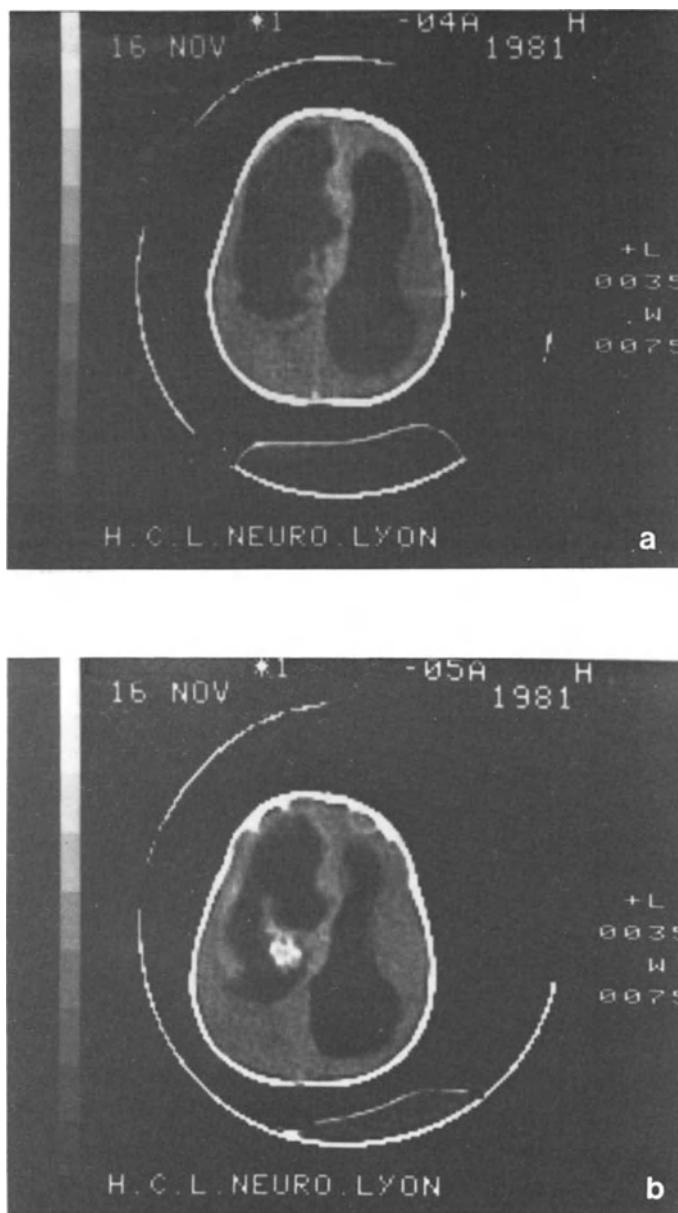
Grade IV ependymoma. a) Pre-contrast CT: asymmetric hydrocephalus. No mass is visualized. b) Post-contrast CT is documenting enhancement of a small septal mass
